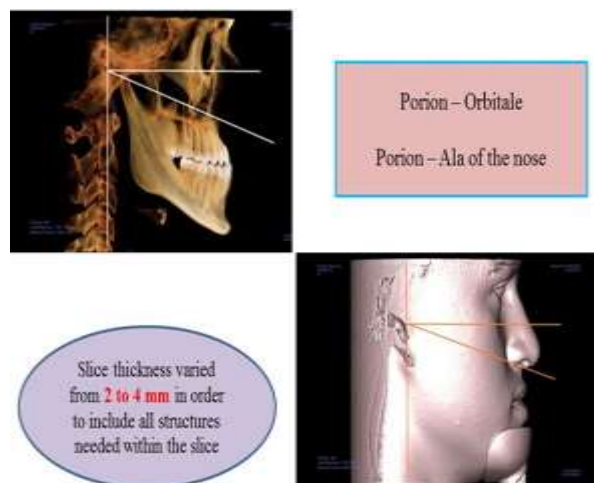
Horizontal & Oblique slices – Mid face area from each CBCT
